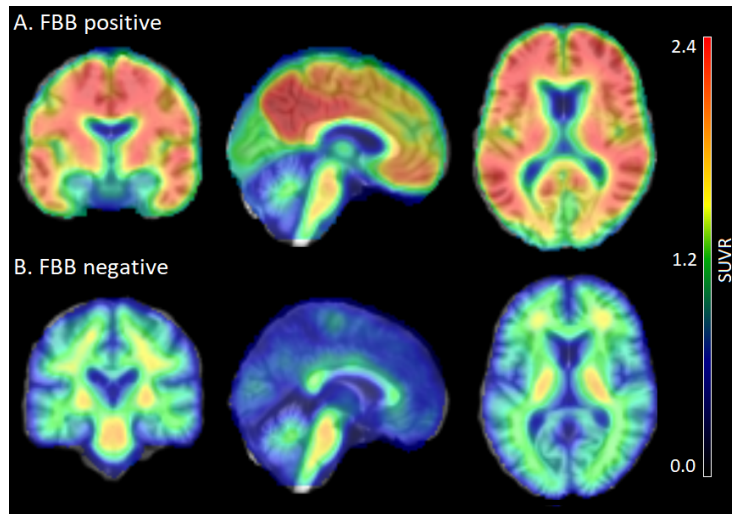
Example FBB PET images given in standard uptake value ratio (SUVR) normalised to the cerebellum, overlaid on skull-stripped T1-weighted structural MRI images. Visual assessment by a trained neuroradiologist classified these subjects as either (A) FBB PET positive, or (B) FBB PET negative.
